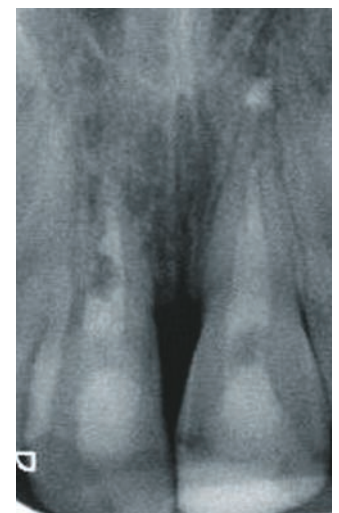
Periapical radiograph one year following the dental trauma. Tooth 11 is ankylosed and is undergoing replacement resorption.
